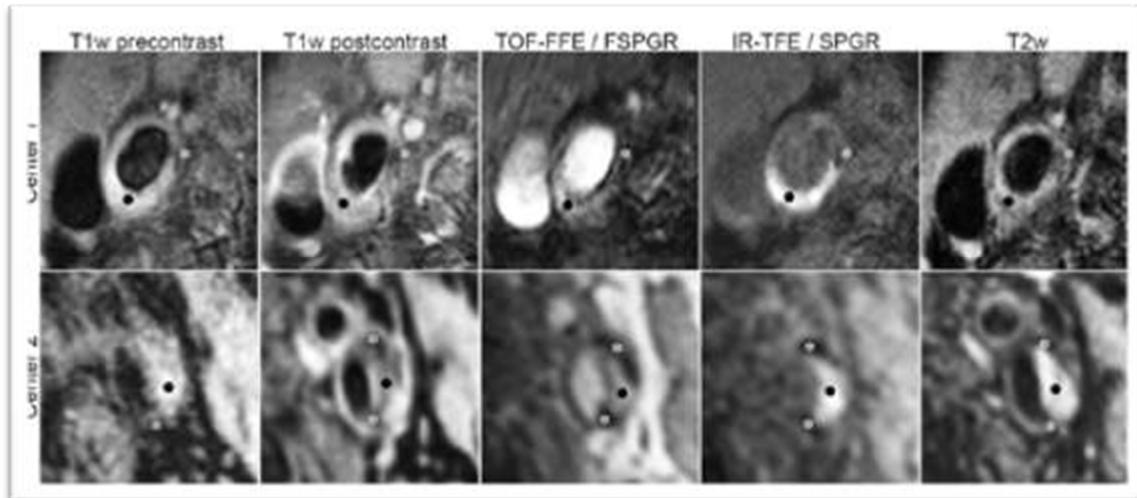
MRI of the carotid artery obtained at two different sites in a multi-centre study to improve diagnosis of high-risk carotid plaques.
